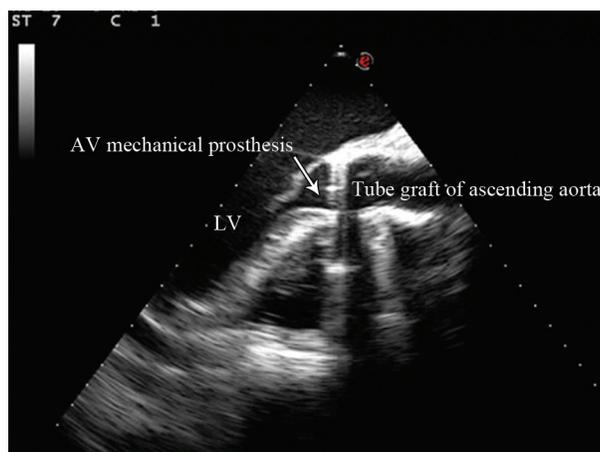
Intraoperative echocardiography after surgical repair: the long-axis view of the aorta (tube graft with a bileaflet mechanical aortic prosthesis) with normal functioning and no evidence of residual pseudoaneurysm or leakage from the tube graft
